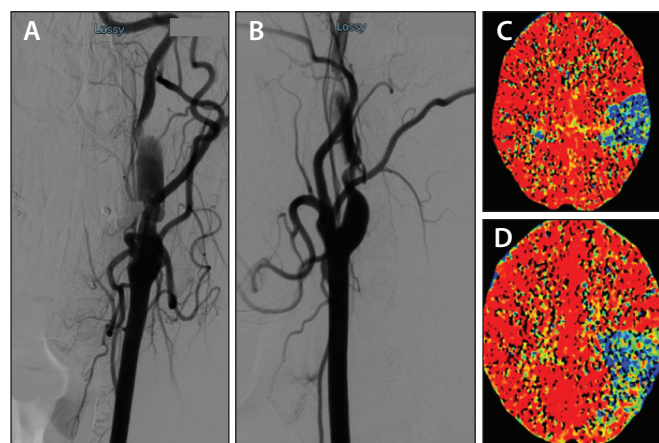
Basal angiography (A, B). Perfusion CT showing the ischemic area (C, D).
